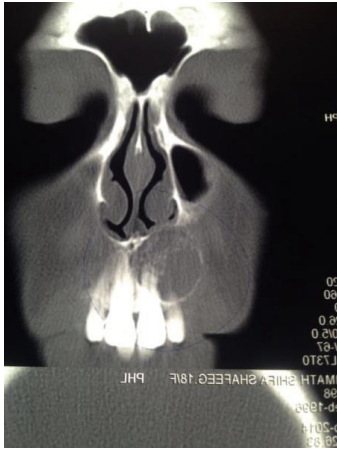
Coronal section CT
